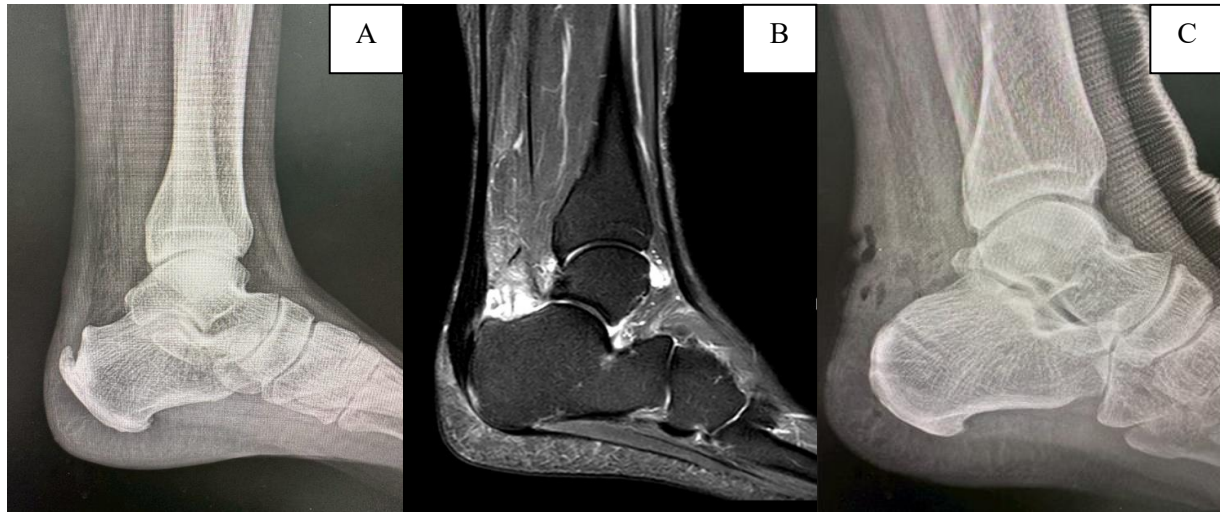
(A) Preoperative lateral radiograph showing a prominent Haglund deformity and calcific enthesophyte at the Achilles tendon insertion, consistent with insertional Achilles tendinopathy. (B) Sagittal STIR MRI of the ankle demonstrating thickening and increased signal intensity of the distal Achilles tendon at its calcaneal insertion, associated retrocalcaneal bursitis, and a posterosuperior calcaneal prominence consistent with Haglund deformity. (C) Postoperative lateral radiograph demonstrating resection of the posterosuperior calcaneal prominence and restoration of a smooth posterior calcaneal contour at the Achilles insertion.
